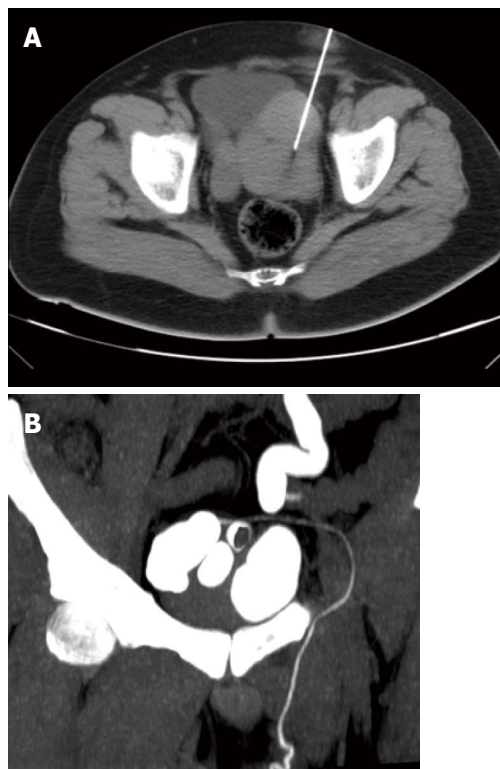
Axial computed tomography. A: The pelvis with needle punctures of the left seminal vesicle; B: Contrast opacification of the seminal vesicle, vas deferens and left ureter stump.
